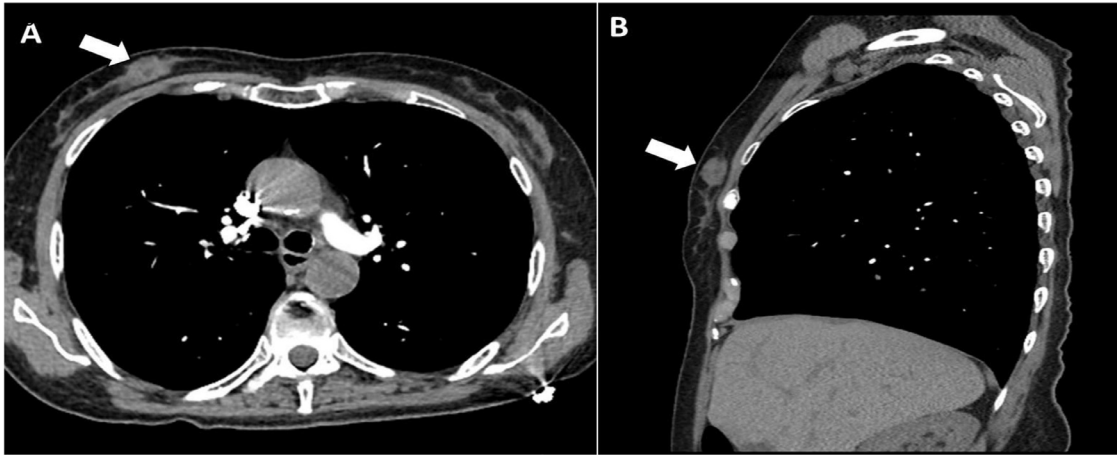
Axial (A) and sagittal (B) CT angiography (CTA) images of the chest performed to rule out pulmonary embolism, incidentally detected approximately 2.5 cm asymmetric soft tissue mass in the superomedial aspect of the right breast (arrows).
